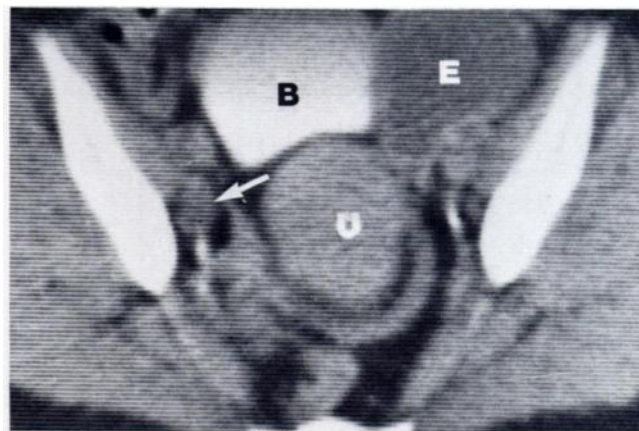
Stage IIB cervix carcinoma. CT scan through bladder (B) and uterine corpus (U). A 2 cm right obturator lymph node metastasis (arrow) and left ovarian endometrioma (E) confirmed at laparotomy.
